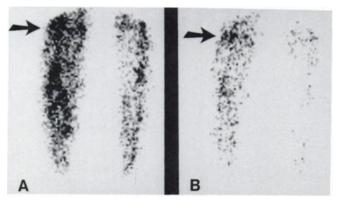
A patient with a deep venous thrombosis in the proximal crural region of the right leg (arrow). Scintigrams obtained 60 min (A) and 80 min (B) after a radiolabeled t-PA specific antibody injection. t-PA was injected immediately after the A scintigram was obtained.
